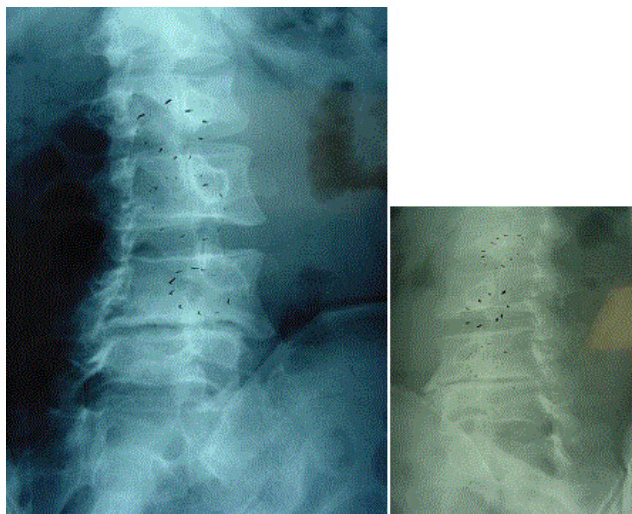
Right Oblique (a) and left oblique (b) radiograph showing 4 separate levels of bilateral pars defect spondylolysis.
